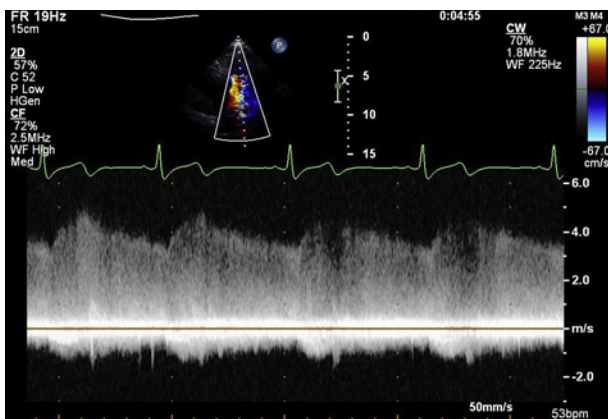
Continuous-wave Doppler interrogation of a PDA demonstrating systolic and diastolic flow toward the pulmonic valve.
